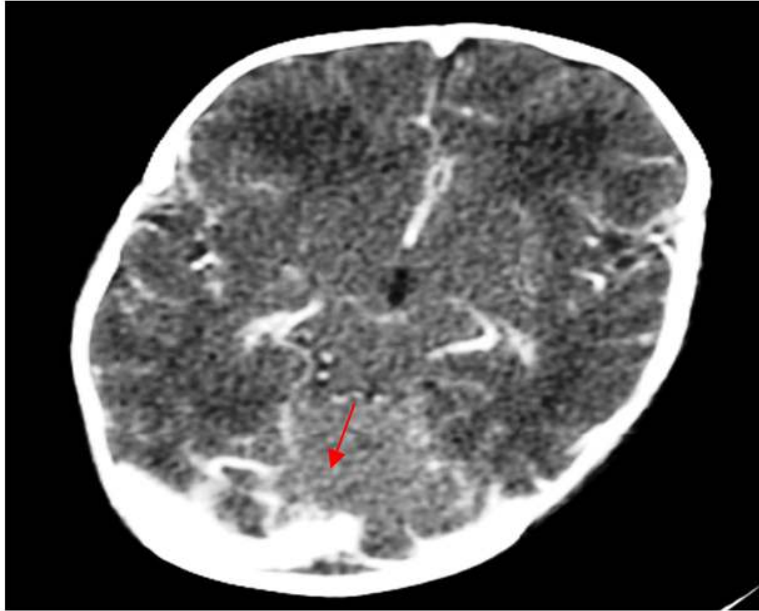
Brain CT: An infant of 36 week's postconceptional age and IUGR with siezure, slit- like lateral ventricle due to brain edema and tiny hyperdensity in posterior fossa due to cerebral venous sinus thrombosis
